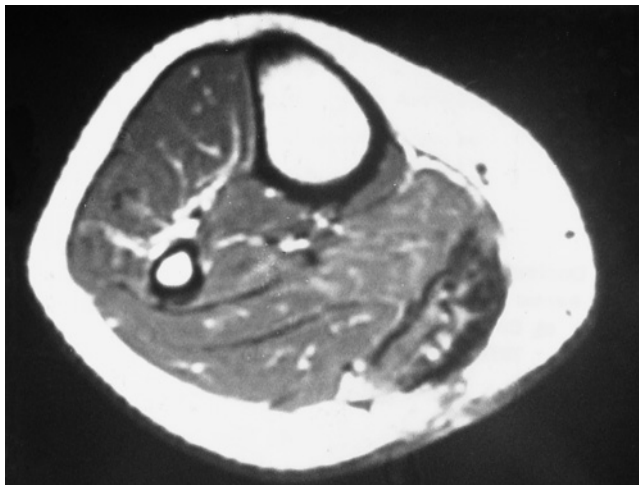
Magnetic resonance image of the medial calf a few weeks after inadvertent intra-arterial injection had produced muscular weakness and pain. Note atrophy of gastrocnemius muscles with significant edema within fascial compartments. (Courtesy Professor Jean Natali, Paris.)
